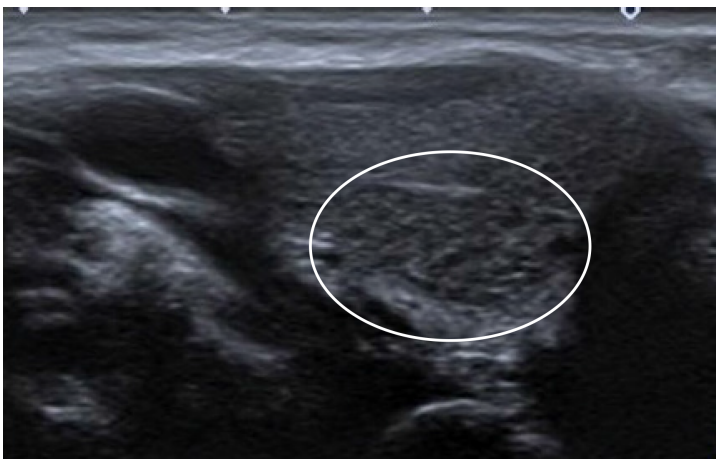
Ten-year-old male with recurrent cough. Longitudinal sonographic images obtained with 7 MHz linear transducer. Abutting type intrathyroidal ectopic thymus. The lesion is located at the lower half of the gland, it has unclear margins. This appearance can be confused with focal thyroiditis.
